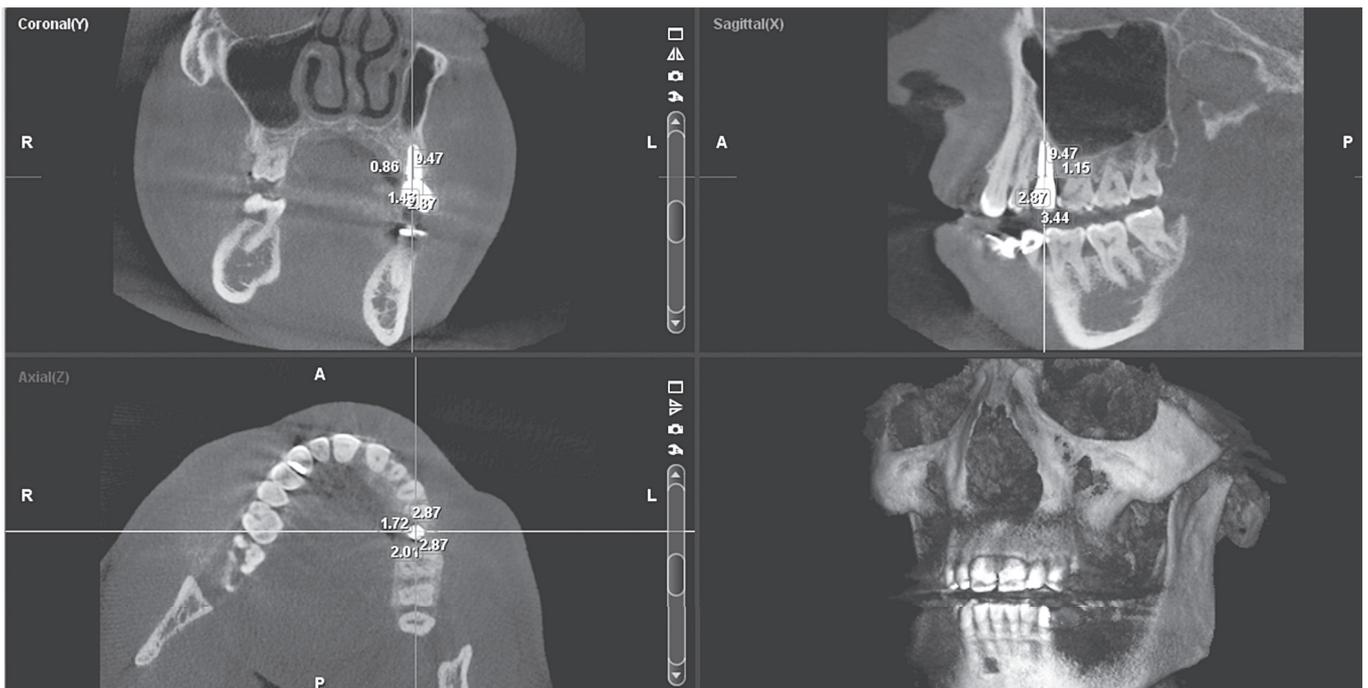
CBCT image, linear measurements using 3D explorer option of Planmeca Romexis® software at 3 different views (a. coronal, b. sagittal and c. axial) with its standardization
